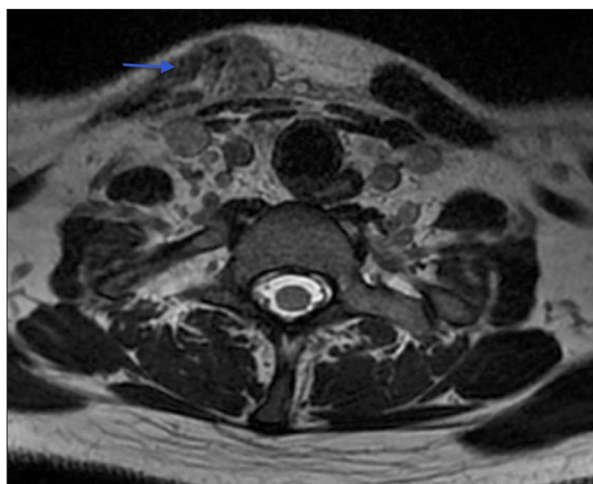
Cervical spine MRI without contrast reveals the edema and enhancement (arrow) of the right SCM compared with the left SCM; finding is consistent with inflammation.
